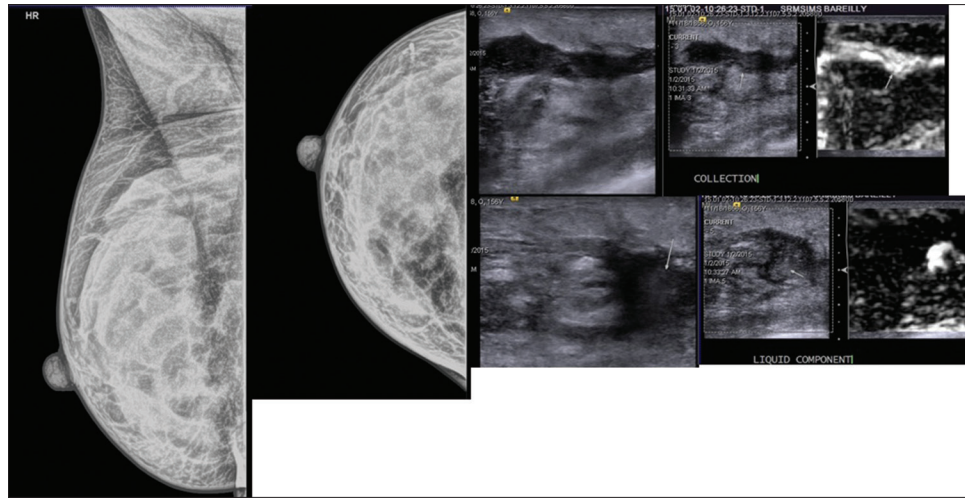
Mammography was non-specific, sonography showed large ill-defined heterogeneous area with necrotic component. Aspiration revealed pus
